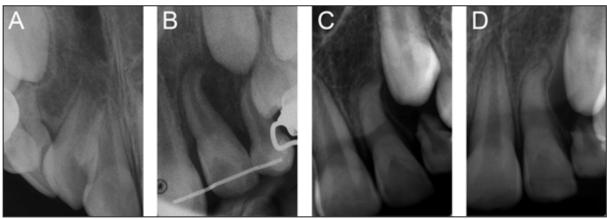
Periapical radiographs: A. Pre-treatment radiograph showing maxillary supplemental supernumerary tooth with incomplete root formation; B. Periapical radiograph immediately after the autotransplantation procedure showing the splinted autotransplanted supplemental supernumerary tooth; C. Periapical radiograph a month following the procedure demonstrating normal signs of healing around the transplanted supplemental supernumerary tooth; and D. Periapical radiograph at the one year follow-up confirming a normal bony development surrounding the transplanted supplemental supernumerary tooth.
